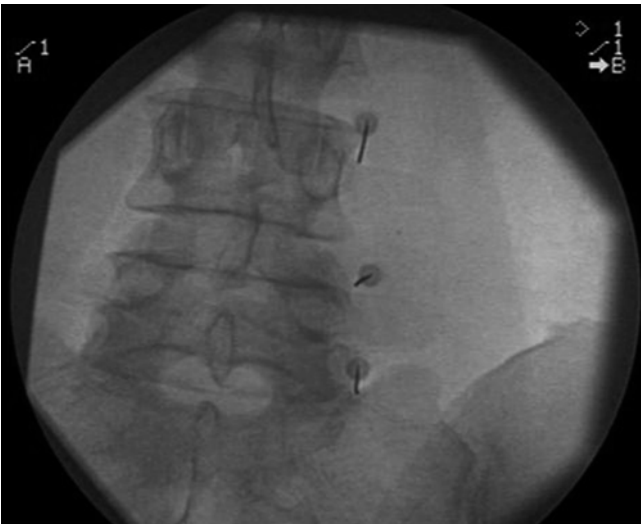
Lumbar facet denervation – X-ray – axial view
